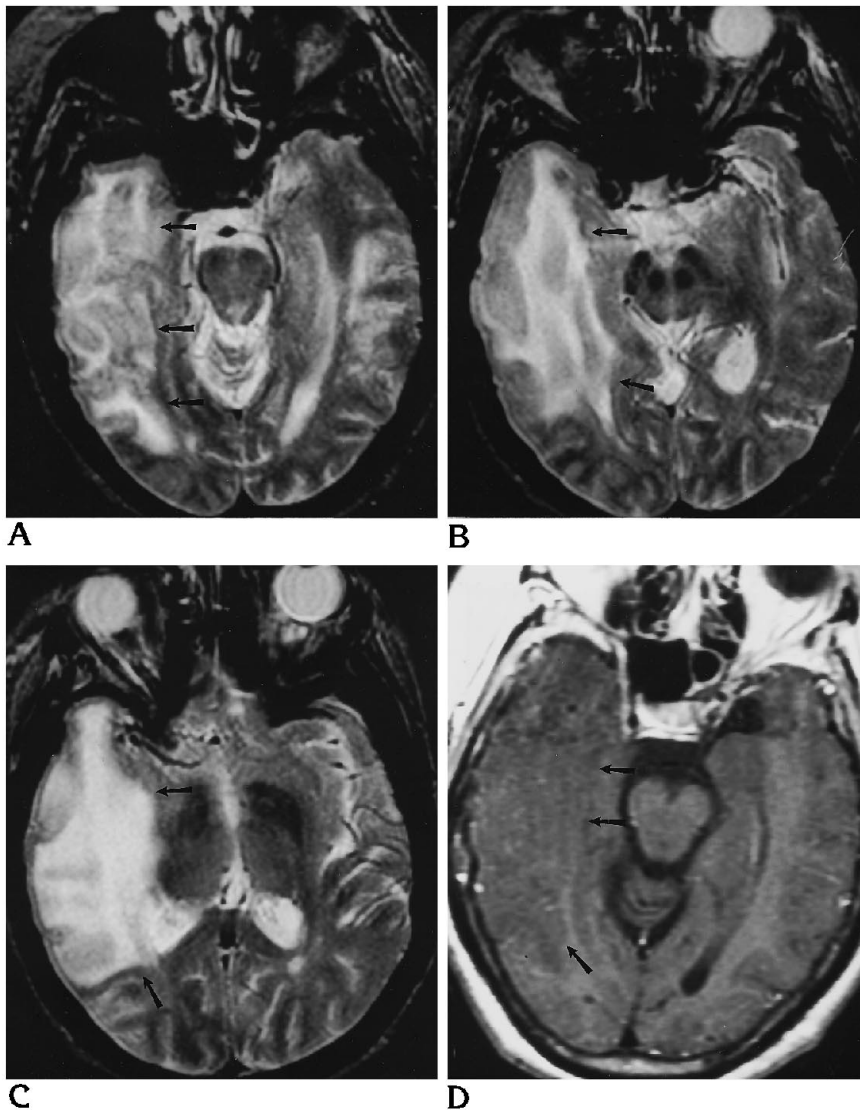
Axial T2-weighted MR images (2100/80) (A–C) and contrast-enhanced T1-weighted image (500/20) (D) obtained at the same time as Figure 2.
